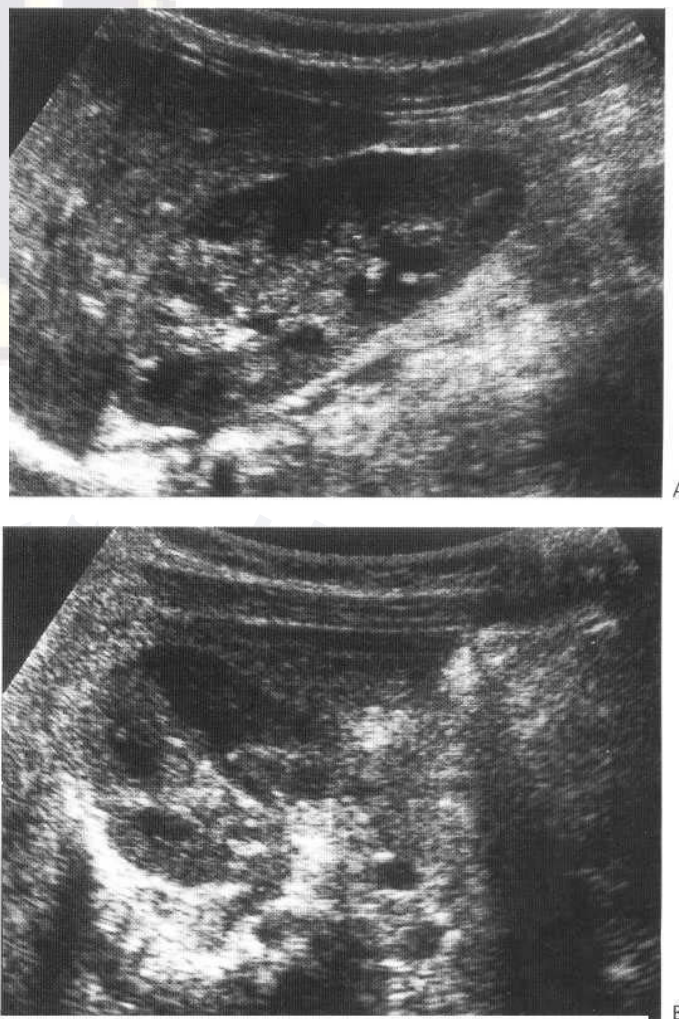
Renal ultrasound. Coronal (A) and transverse (B) images of the kidney of a 10-year-old child. The medullary pyramids are less conspicuous than in the neonatal period and there is now some echogenicity around the renal hilum.
